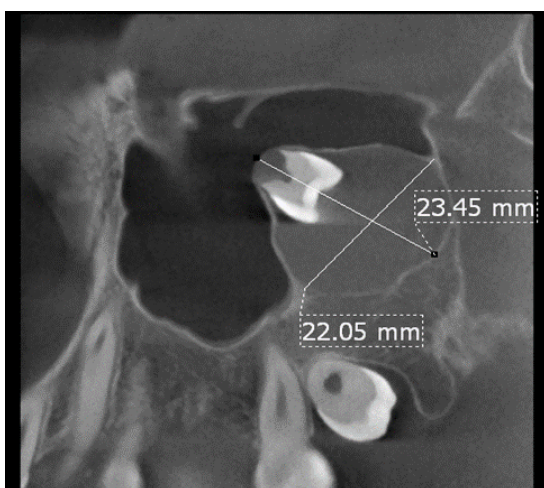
CT Cone-Beam Neurilemmoma associated with and displacing the upper left third molar.
